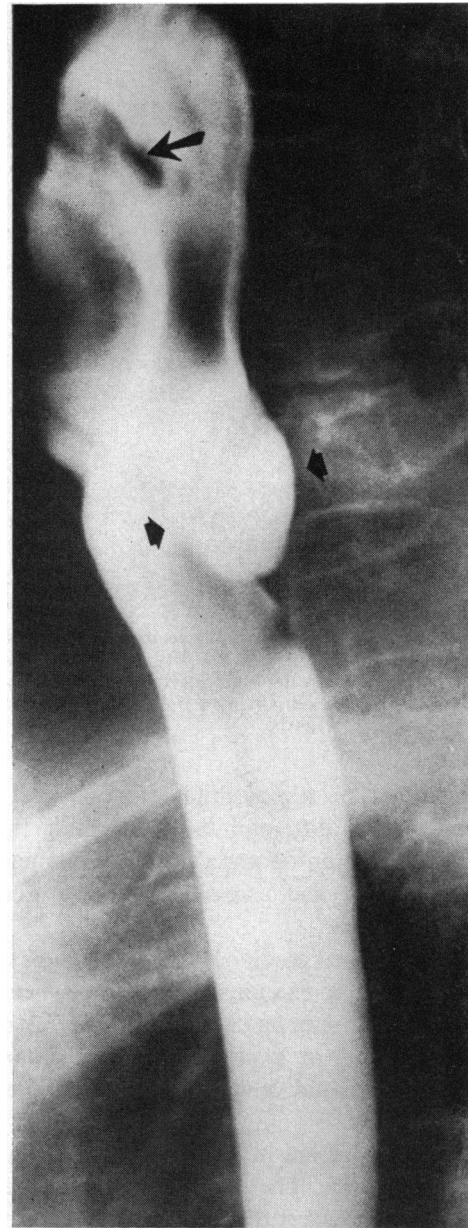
Zenker’s diverticulum. Lateral radiograph demonstrates the barium-filled pharynx (epiglottis identified by large arrow), diverticulum (small arrows) and upper esophagus. The diverticulum has displaced the esophagus forward. Because the diverticulum also lies lateral to the esophagus, it overlaps the barium-filled esophageal lumen. (Through courtesy of McGraw-Hill publishers, “Diagnostic Radiology—A Companion to Harrison’s Principles of Internal Medicine,” P. Ruben Koehler, M.D., editor.)
